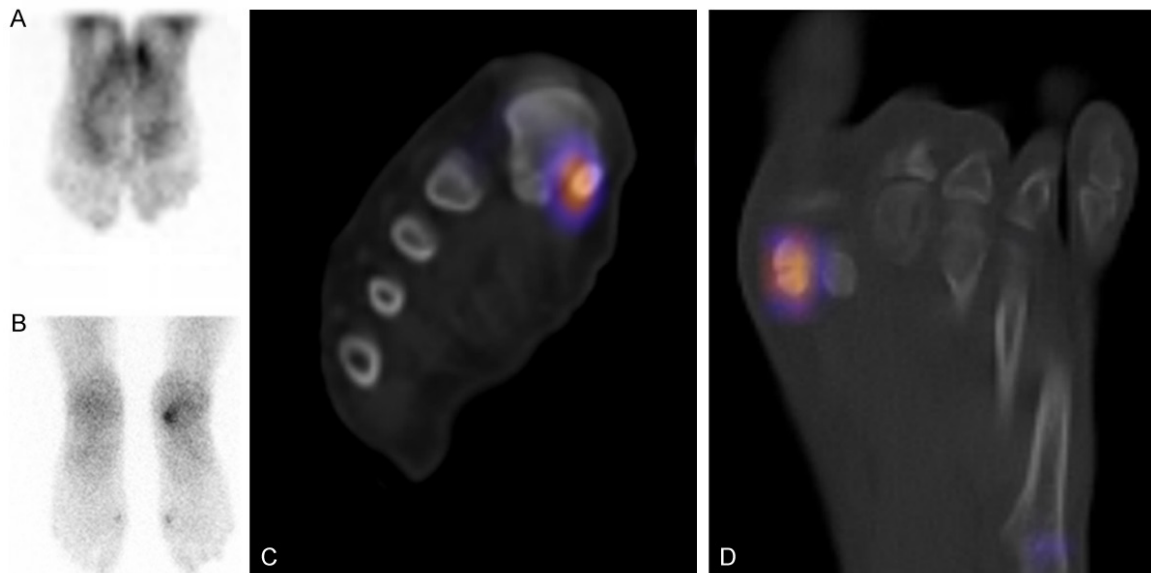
Focal increased uptake on delayed planar image (B) and SPECT-CT (C) in the tibial sesamoid bones bilaterally without significantly increased activity on blood pool images (A), attributed to sesamoiditis. In this case, the focal increased uptake in the right talus corresponds to remote talar fracture. SPECT-CT (D) images of a different patient demonstrates focal increased uptake with associated fracture of the left tibial sesamoid bone.
